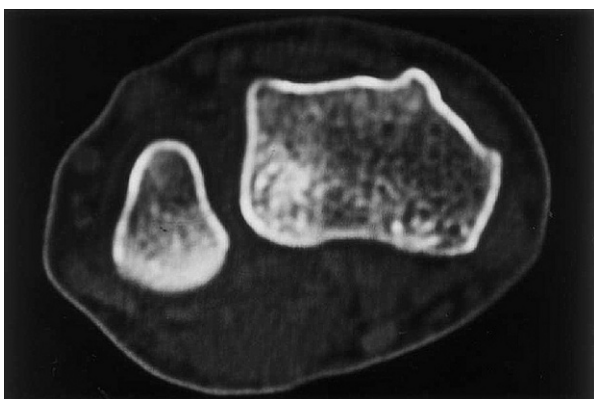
A preoperative axial CT scan of the left wrist in full supination shows a flat sigmoid notch with volar dislocation of the DRUJ. Reprinted with permission from Wallwork NA, Bain GI. Sigmoid notch osteoplasty for chronic volar instability of the distal radioulnar joint: a case report. *J Hand Surg.* 2001;26:454–459.
